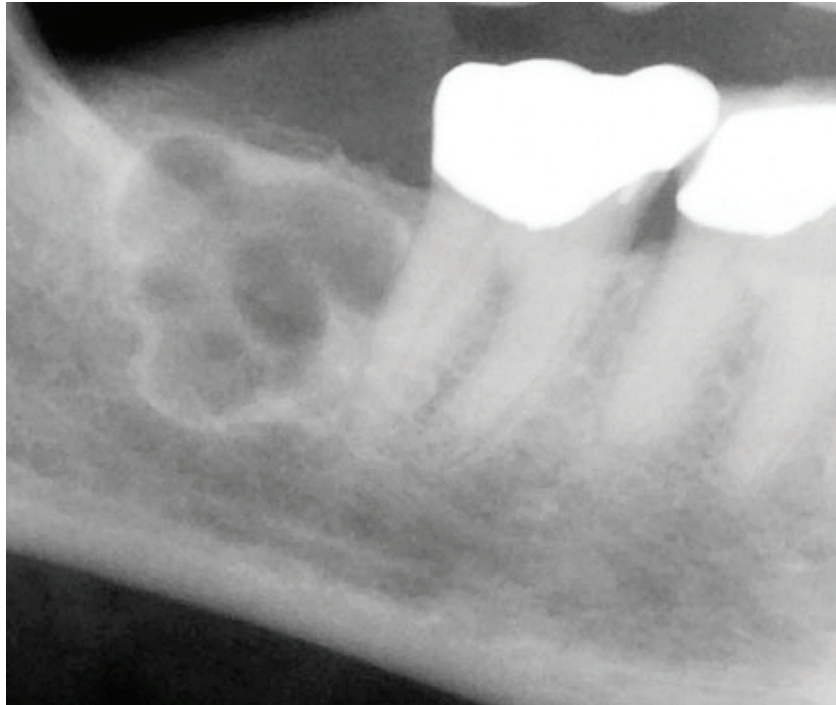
Radiograph showing a well-defined, multilocular radiolucency in the right posterior mandible.
